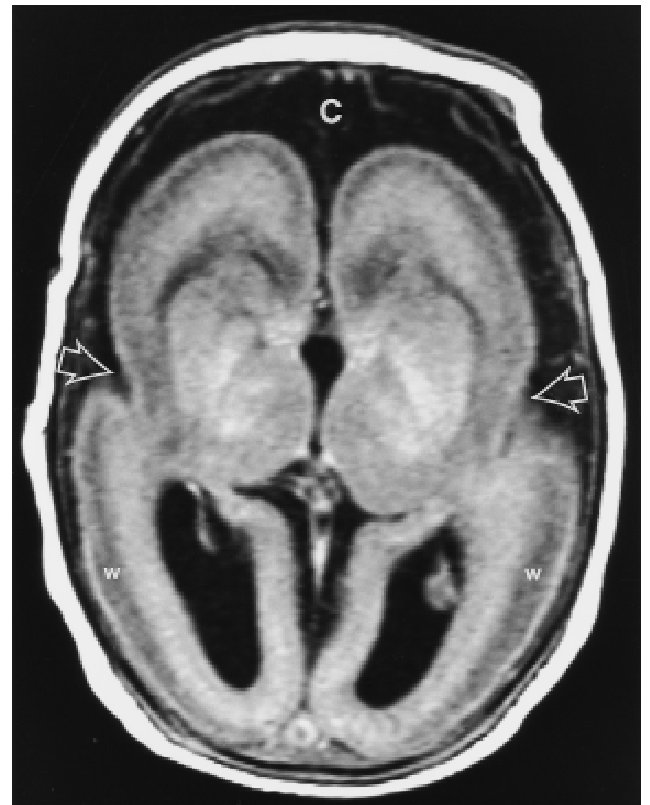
MRI of the newborn infant (axial T1 weighted TR500/TE20) shows diffuse and complete type I lissencephaly. There is a thin outer cortical layer separated from a thicker, inner cortical layer by a layer of white matter (W). On this MRI, the white matter (W) appears slightly grey in contrast to the cortex, which has a lighter shade. Primitive Sylvian fissure (open arrows) are visible bilaterally and give rise to a "figure 8" appearance of the brain. The posterior horns of the ventricular system have a persistent fetal configuration also called colpocephaly. Prominent CSF spaces (C) are seen over the convexities. Hypogenesis of the corpus callosum and a normal cerebellum (not shown) were also confirmed on MRI.
